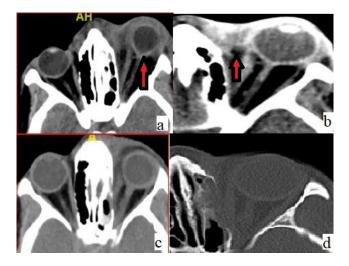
(a): Posterior tenting of the left globe (guitar pick sign) (red arrow) (b): LE extraconal abscess anteromedially with medial extraconal fat stranding (red arrow) (c): Postcanthotomy and cantholysis, CT showing left optic nerve thickening and reduction of proptosis and posterior nerve stretch and posterior globe tenting; (d): CT at 3 months follow up showing normal findings
